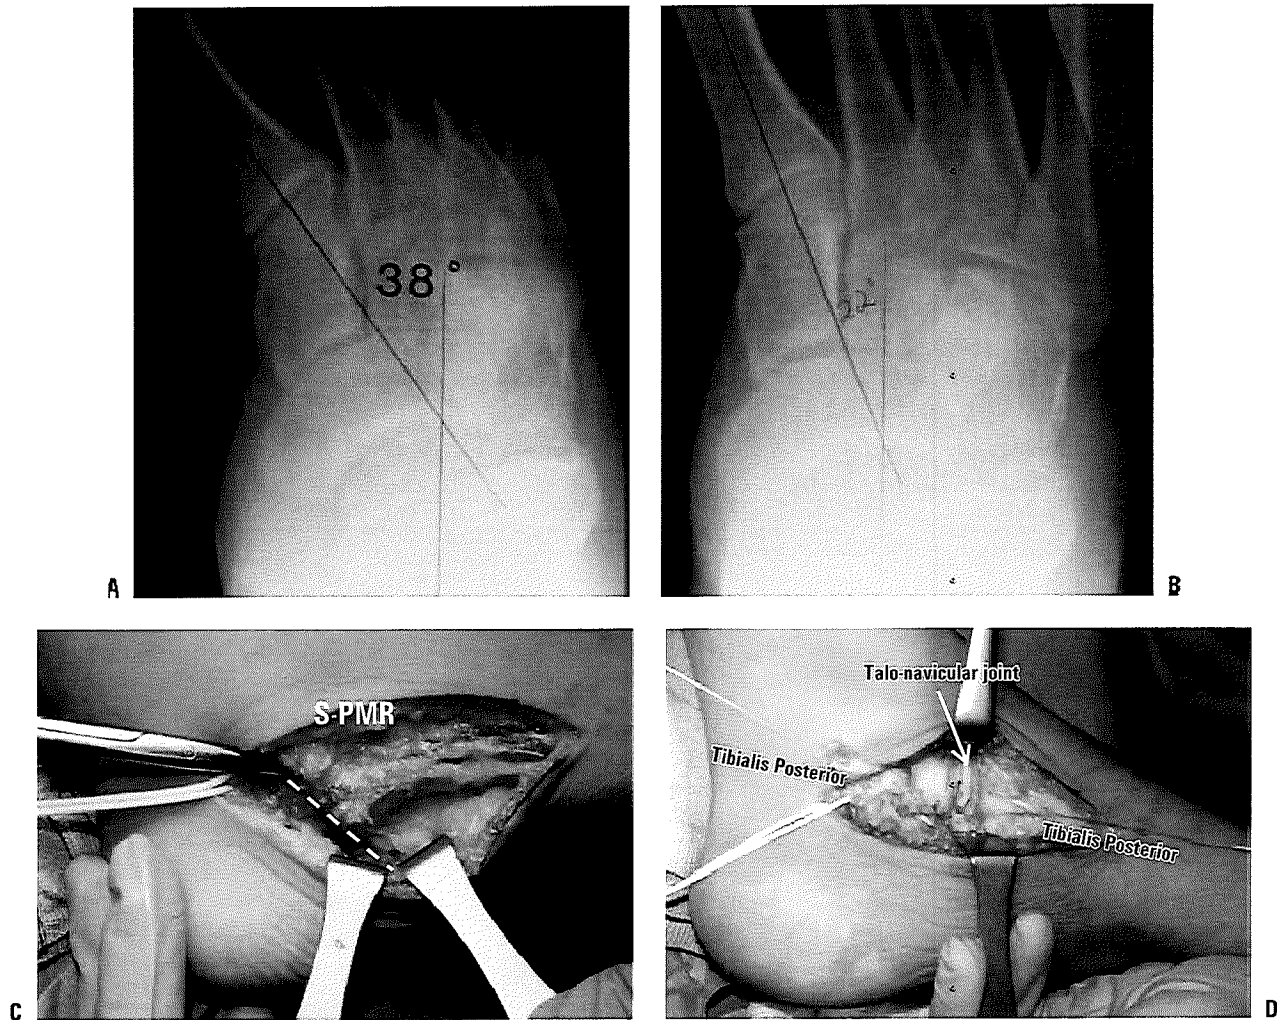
Superficial and deep plantar-medial releases. A: Standing AP x-ray of a cavovarus foot. The foot-CORA is in the talonavicular joint, confirming that the deformity is hindfoot varus and not midfoot adductus. B: The varus deformity does not correct fully, as confirmed by a standing Coleman-type block test x-ray. The foot-CORA is still in the talonavicular joint, but the forefoot axis (and acetabulum pedis) is still medially deviated. This is the indication for a deep plantar-medial release. The subtalar joint inversion requires release, just as it would if this were a clubfoot. C: The superficial plantar-medial release is performed first. Besides providing the necessary release of the contracted more superficial structures, it provides access to the deep structures. D: Deep plantar-medial release. The tibialis posterior tendon is Z-lengthened and the talonavicular joint is released dorsal to plantar, including release of the spring (calcaneo-navicular) ligament. Again consider the analogy to a clubfoot release. (From the private collection of Vincent S. Mosca, MD.)
